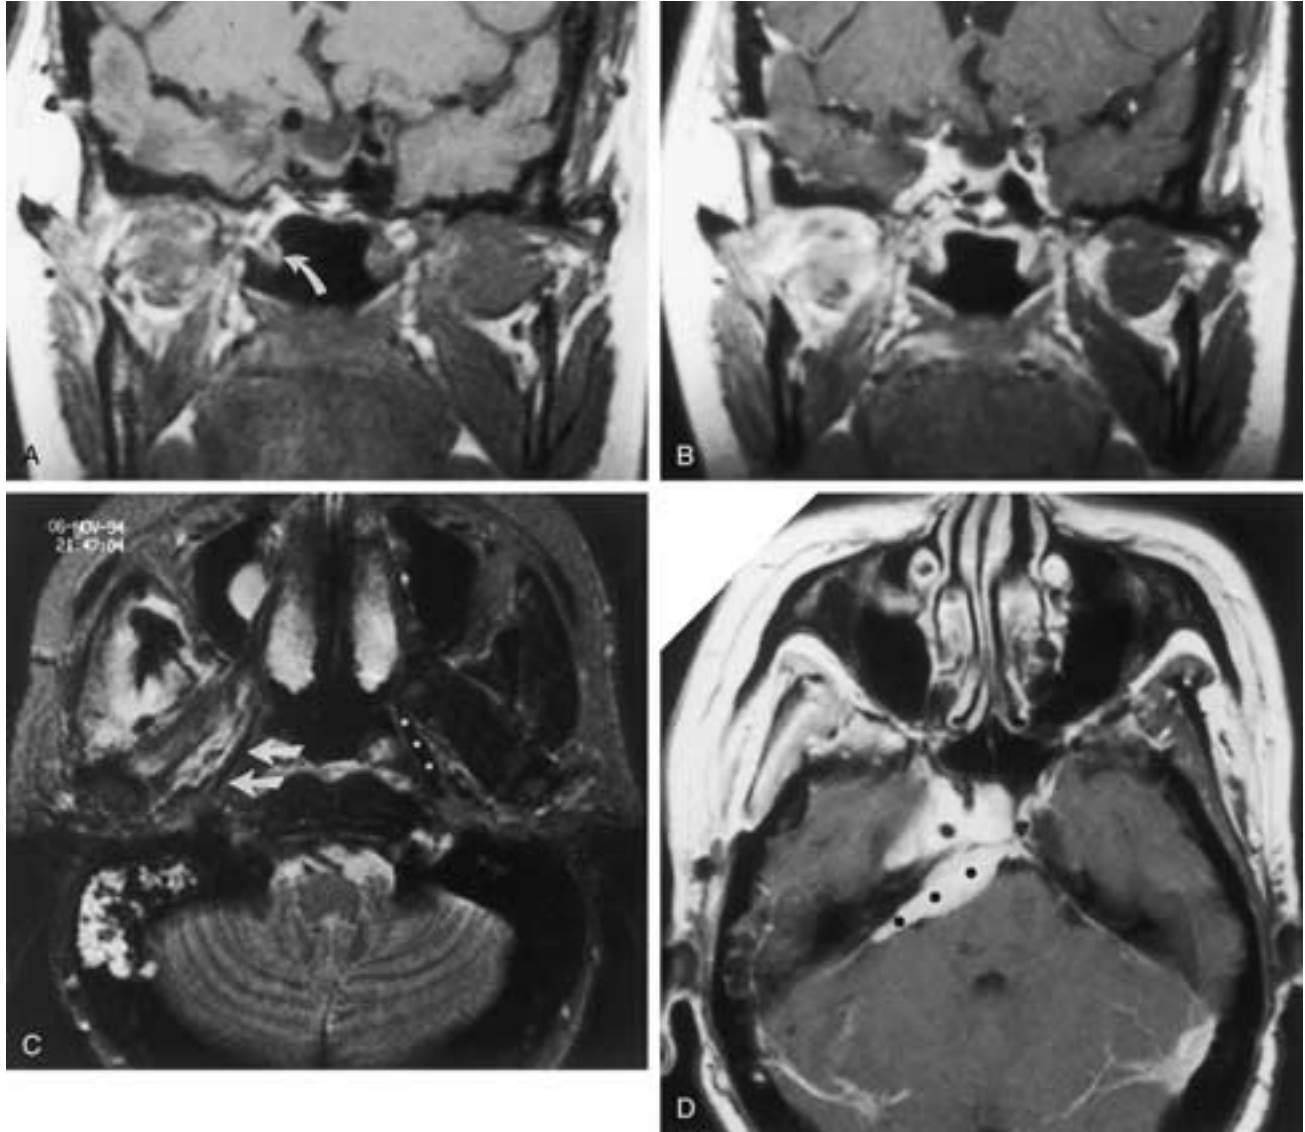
Subacute V3 denervation. A, Coronal T1-weighted MR image demonstrates some fatty infiltration and mild volume loss of the right muscles of mastication. Note the diminutive right torus tubarius, which may be related to tensor veli palatini dysfunction (*arrow*). B, Coronal contrast-enhanced T1-weighted MR image demonstrates enhancement of the right muscles of mastication. C, Axial T2-weighted MR image reveals significant fluid within the right mastoid air cells due to tensor veli palatini dysfunction. Note the diminutive size of the right tensor veli palatini muscle (*arrows*) compared to the normal muscle on the left (*dots*). D, Axial contrast-enhanced T1-weighted MR image demonstrates the causative lesion to be meningioma affecting the trigeminal nerve in its cisternal and cavernous sinus segments (*dots*).
